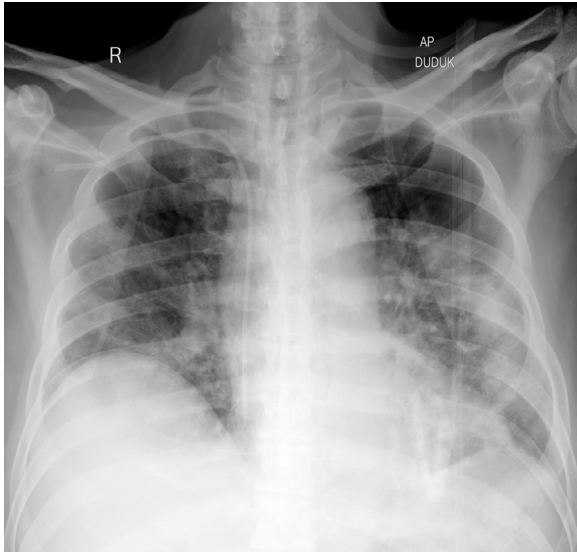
Chest X-ray on day 20 shows improvement, bilateral Pneumonia was still seen, and no more pneumothorax, pneumomediastinum, and emphysema subcutis were detected.
